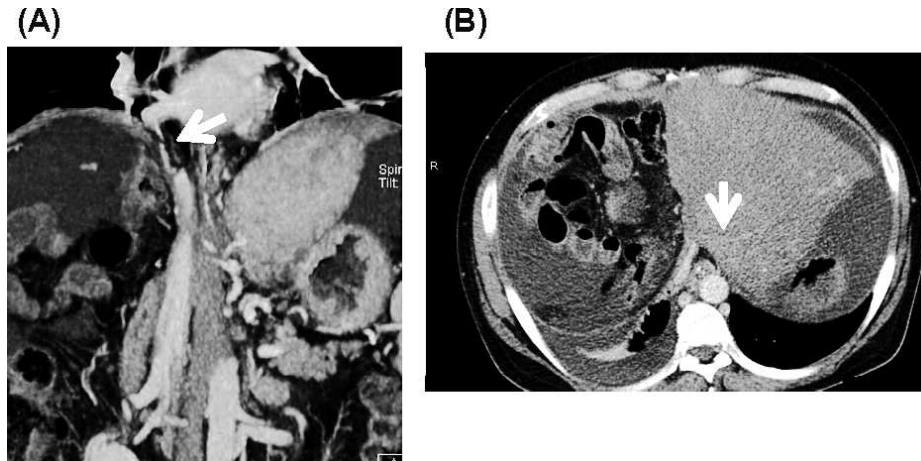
Enhanced CT revealed stenosis of (A) the inferior vena cava on frontal section (arrow), and of (B) the left hepatic vein on transverse section (arrow).
